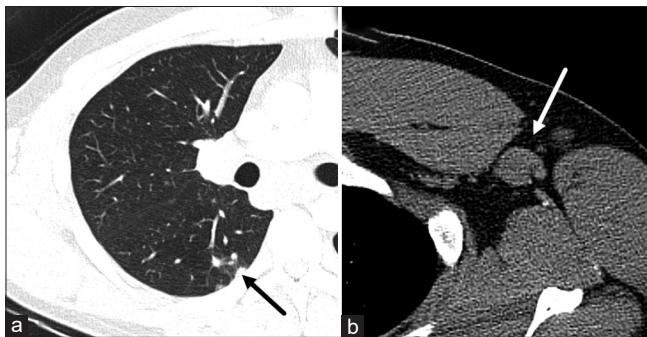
(a) Axial chest computed tomography image demonstrates "tree-in-bud" nodularity (black arrow) in this patient with pathologically proven Blau Syndrome. (b) Coned-down chest computed tomography in soft-tissue window of the same patient demonstrates left axillary adenopathy (white arrow)
